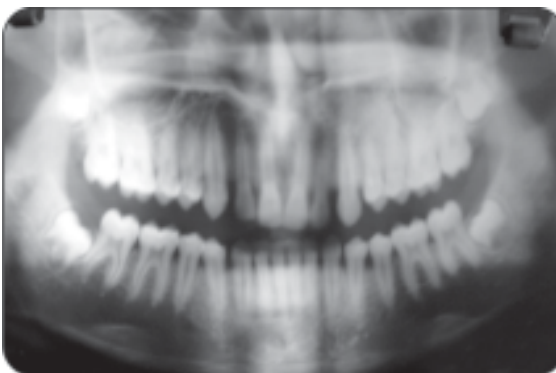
Radiographic view of fibrous dysplasia
